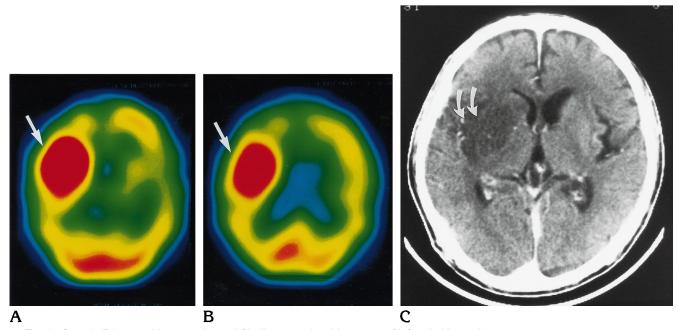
Case 1: 71-year-old man with atrial fibrillation and sudden onset of left-sided hemiplegia. A and B, HMPAO SPECT scans 4 hours after the onset of stroke show marked elevation of 99m Tc-HMPAO uptake (arrows) in the right frontal, temporal, and parietal lobes, including the striatocapsular region.
